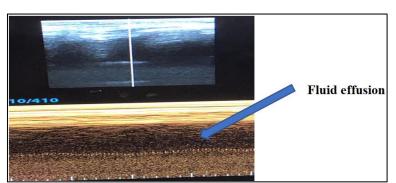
Pleural ultrasound showing a sinusoidal appearance of the visceral pleura
